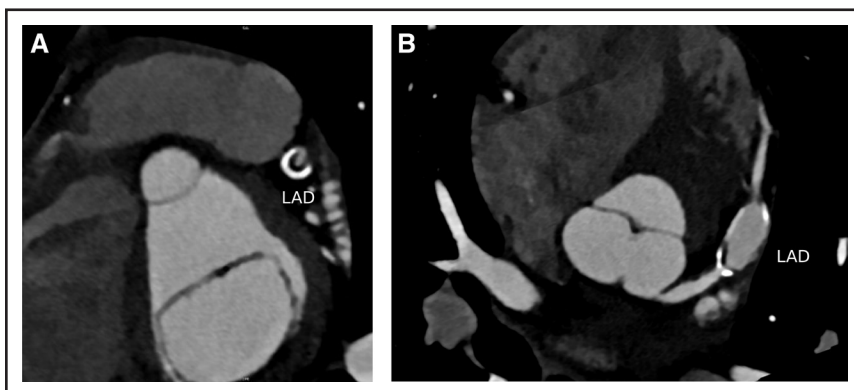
Coronary computed tomography angiography.
